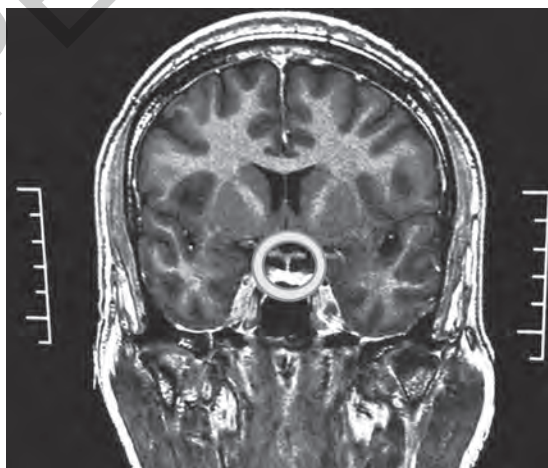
MRI at follow up visit. Note the resolution of mass and clear visualisation of the stalk
